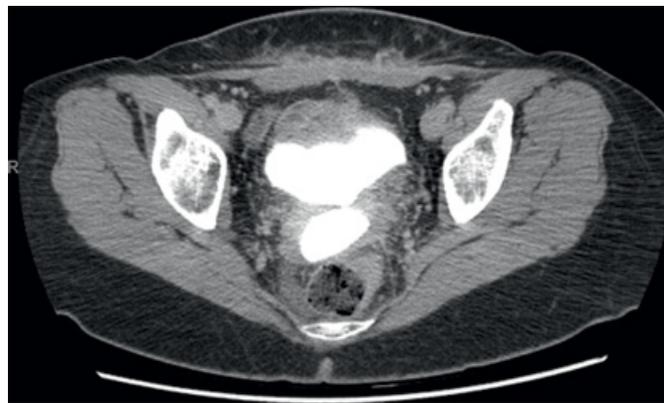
CT cystogram of a vesicovaginal fistula. Contrast present in both bladder and vagina.
